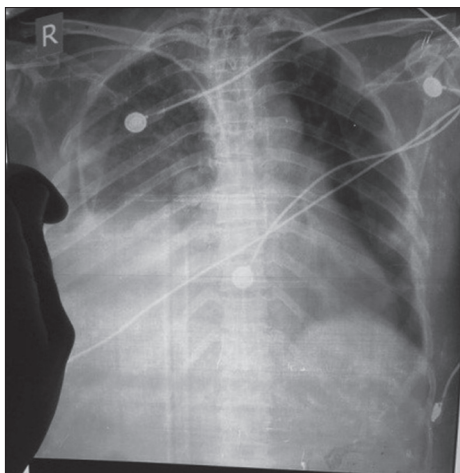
Chest X-ray showing ill-defined contour of the right hemidiaphragm
